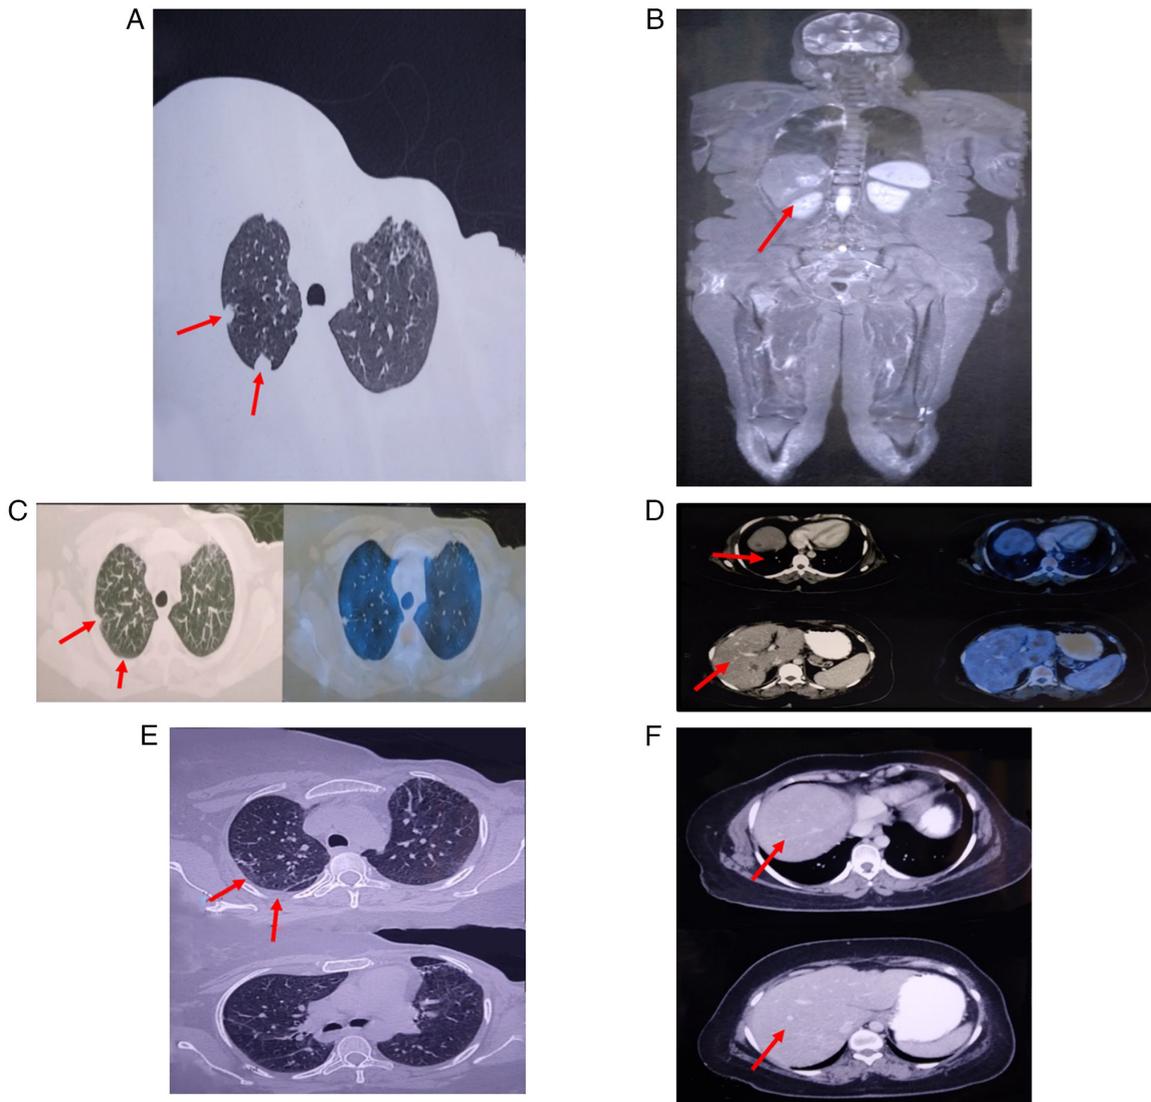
Positron emission tomography-computed tomography-based radiological response to NDLS treatment in a female diabetic patient with hormone receptor-positive metastatic breast cancer. (A) Bilateral lung nodules and (B) multiple liver metastases (arrow) were observed prior to NDLS treatment. Partial response was achieved following six cycles of NDLS, resulting in decreased size of (C) lung nodules and (D) liver lesions. Partial response was sustained following 12 cycles of NDLS, indicated by inactive (E) lung nodules and (F) liver lesions. NDLS, nanosomal Docetaxel Lipid Suspension.
